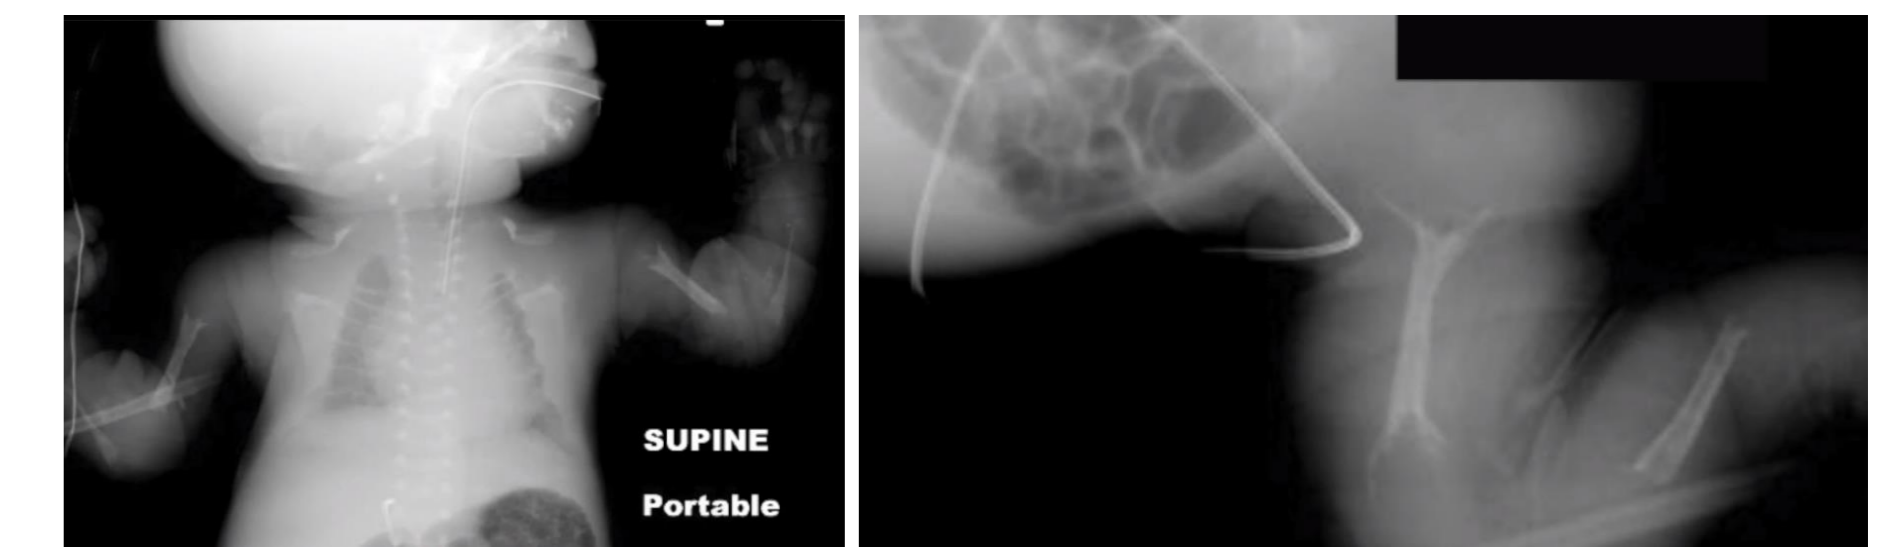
X-Rays of a child with HPP (extracted from a movie on HPP at <http://alexion.com/patients>)
